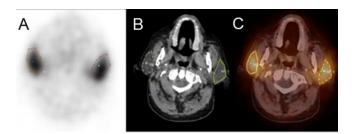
Volume of interest (VOI) (count) and volume (mm³) calculations of Lu-177 PSMA-617 SPECT/CT images respectively, revealed no difference for neither count nor volume parameters. Shown are transaxial SPECT (A), CT (B),fused SPECT/CT (C), and coronal SPECT (D) images.
